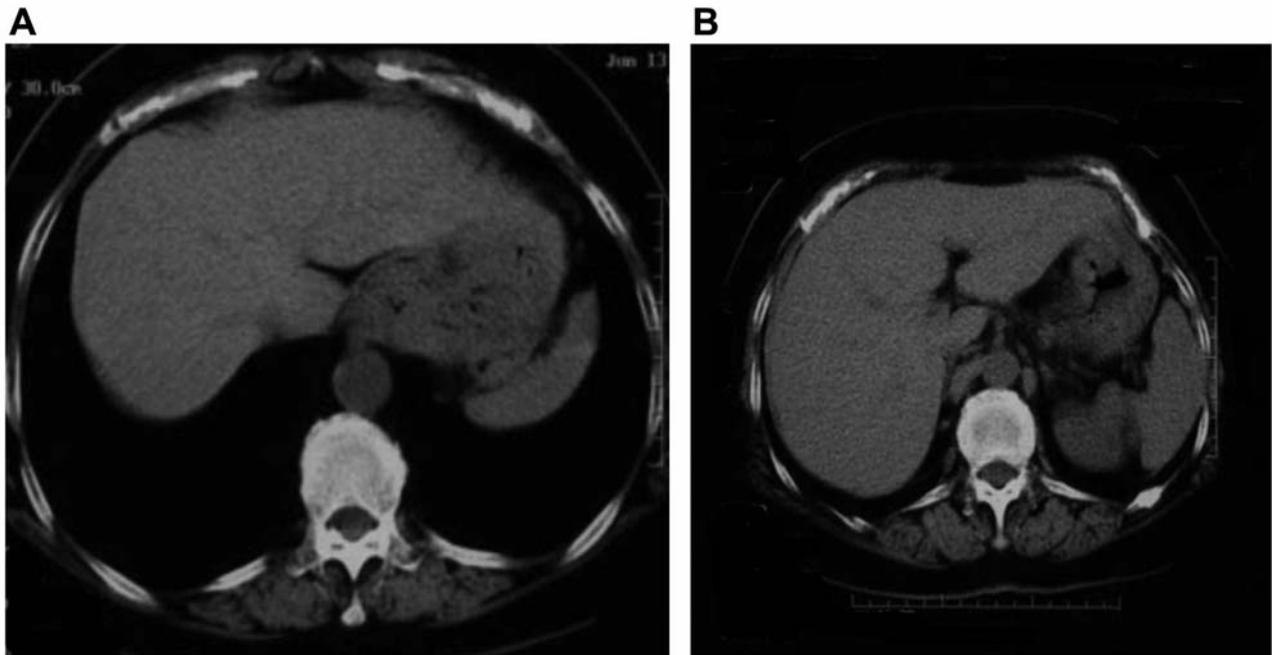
Abdominal computed tomographic scan shows the tumor of the lower esophagus (A) with no evidence of direct invasion to surrounding organs or metastasis to lymph nodes or distant sites (B).
